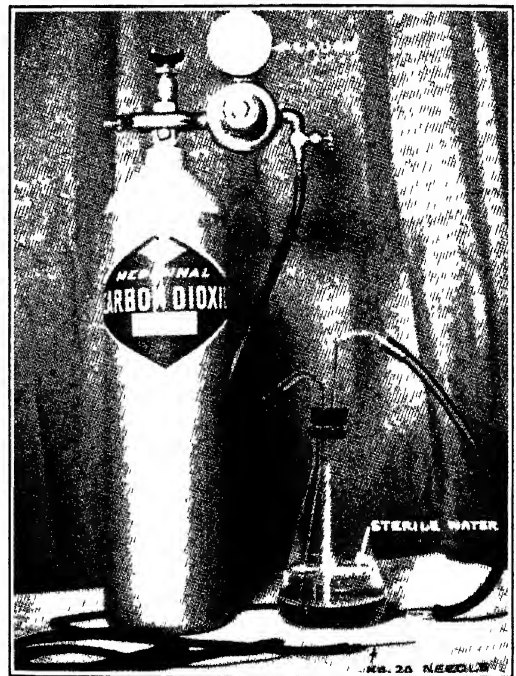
Apparatus devised for CO_2 insufflations of the breast (Am J Roentgenol, March, 1938)
